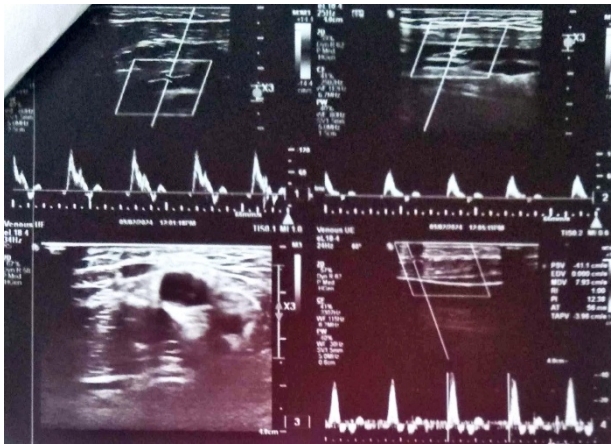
Venous Doppler study showing dilation of the right subclavian vein.
